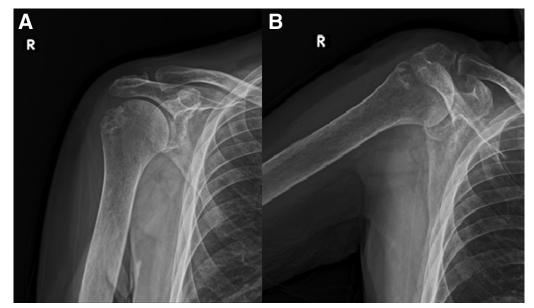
Follow-up radiograph at 6 weeks postoperatively with (A) AP view and (B) AP with abduction view, showing healing of the previously fracture greater tuberosity. (AP, anteroposterior.)
